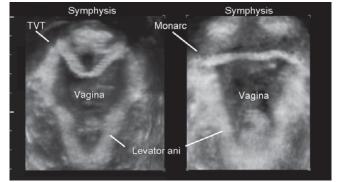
Suburethral slings as seen on translabial ultrasound, axial plane. The TVT (left) is curving ventrally, while the Monarc tracks laterally towards the insertion of the levator ani muscle.
